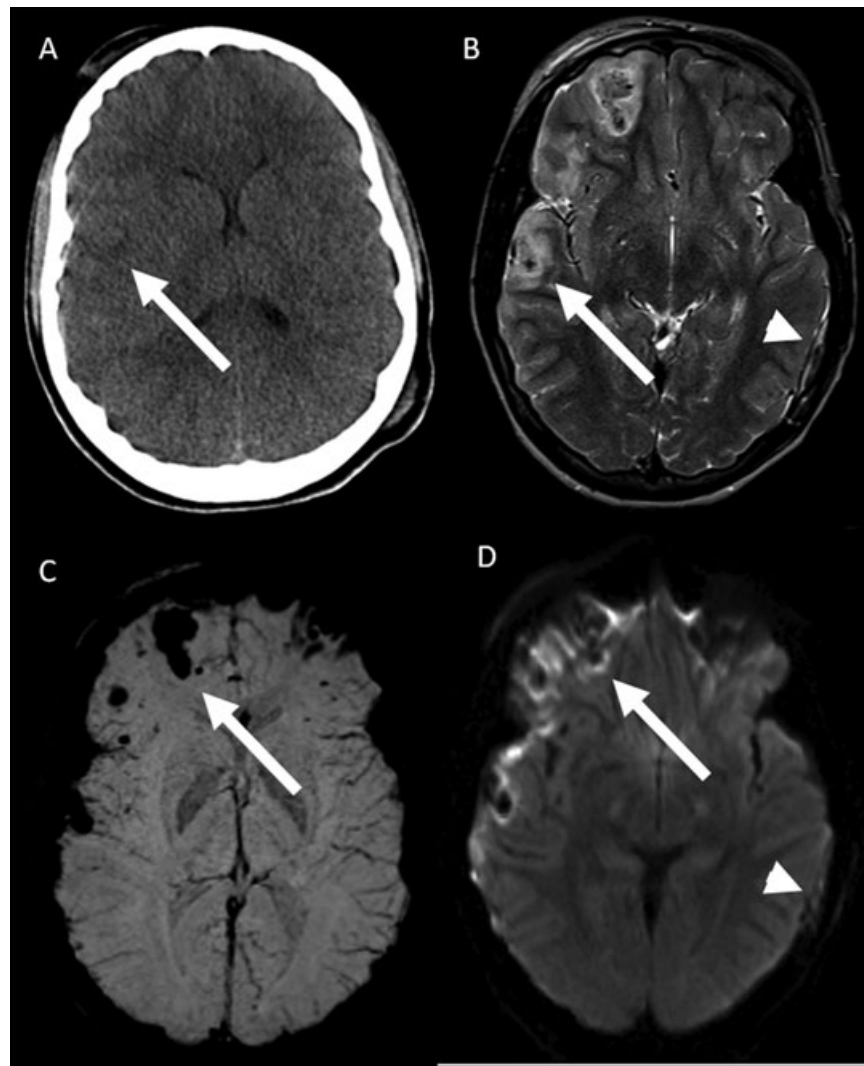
Axial CT (A) and matching T2-weighted (B), SWI (C), and DWI (D) MR images of a child with classical “coup and contrecoup” lesions. The primary impact of force resulted in minimal left temporal cortical (coup) and more extensive right fronto-temporal cortical contusions (contrecoup). The hemorrhagic lesions are best seen on the SWI images (C). The subcortical edema is best seen on the T2-weighted (B) and DWI MR (D) images. The blood products result in mild susceptibility artifacts on DWI. A small extraxial hematoma is seen overlying the left temporal region.
